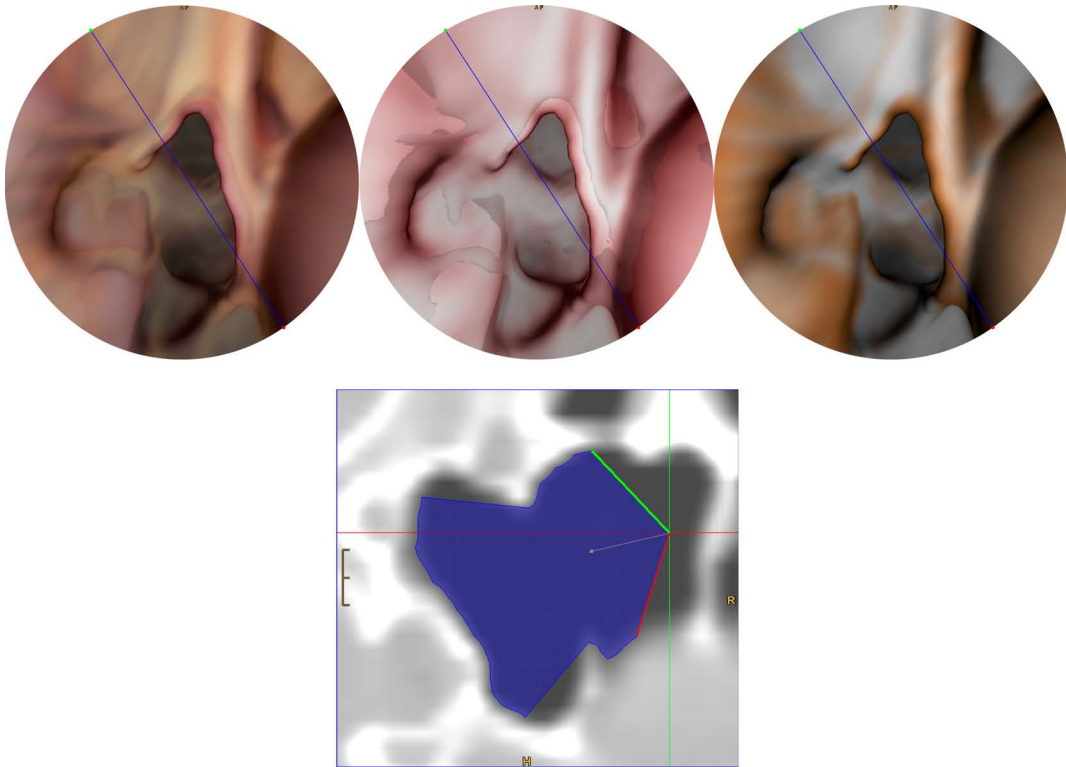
Displaying surface rigidity: Top Left: volume rendering; Top Center: double iso-surfacing; Top Right: color-coding; Bottom: section through original CT data, the blue lines in the 3D images indicate the intersection with this CT slice (see Section 7.2)
